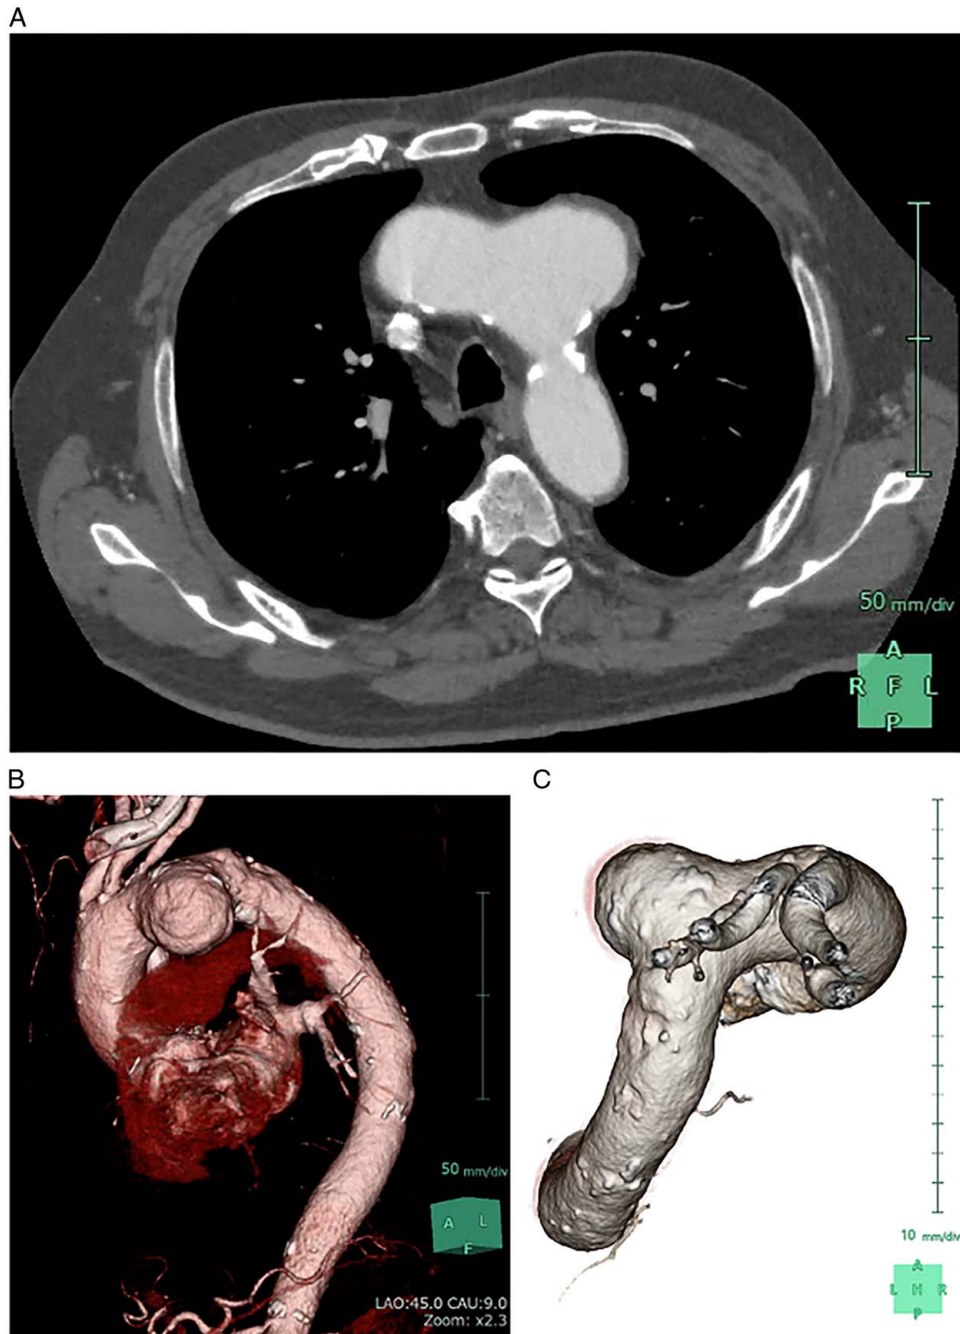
Preoperative enhanced computed tomography (CT). (A) The axial view shows a large aortic aneurysm located anteriorly on the aortic arch. (B, C) Preoperative three-dimensional (3D) CT images.
